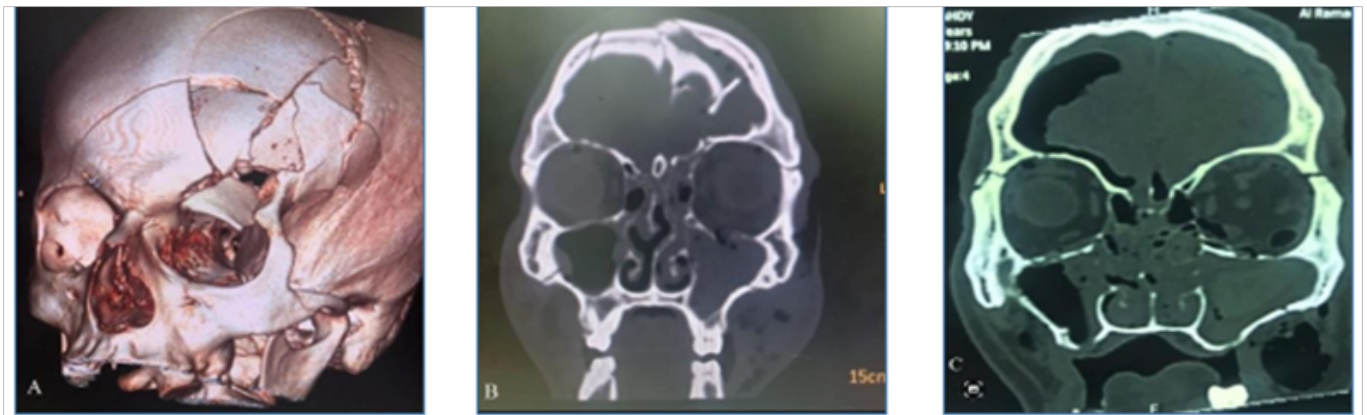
CT scans for different patients with concomitant severe head injury with maxillofacial trauma.
